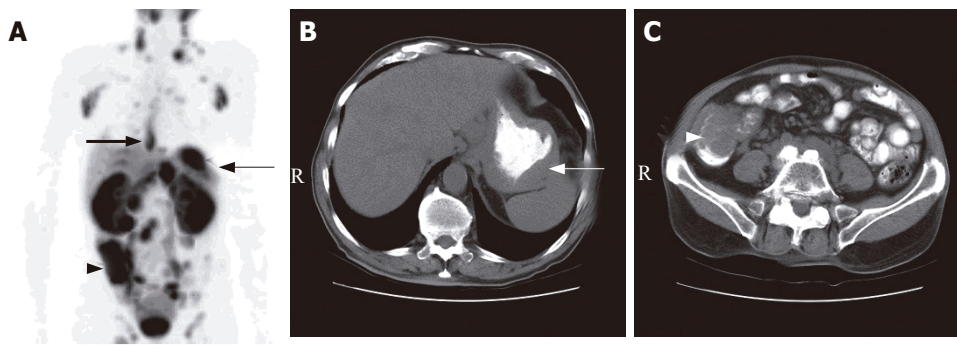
A 78-year-old man with mantle cell lymphoma. A: ^{18}F -FDG PET scan revealed multiple hypermetabolic foci involving the lower esophagus (thick arrow), gastric fundus (thin arrow), cecum and terminal ileum (arrow head); B and C: The corresponding CT scans of the abdomen showed wall thickening at the gastric fundus (white arrow) and the cecum and terminal ileum (white arrow head)
